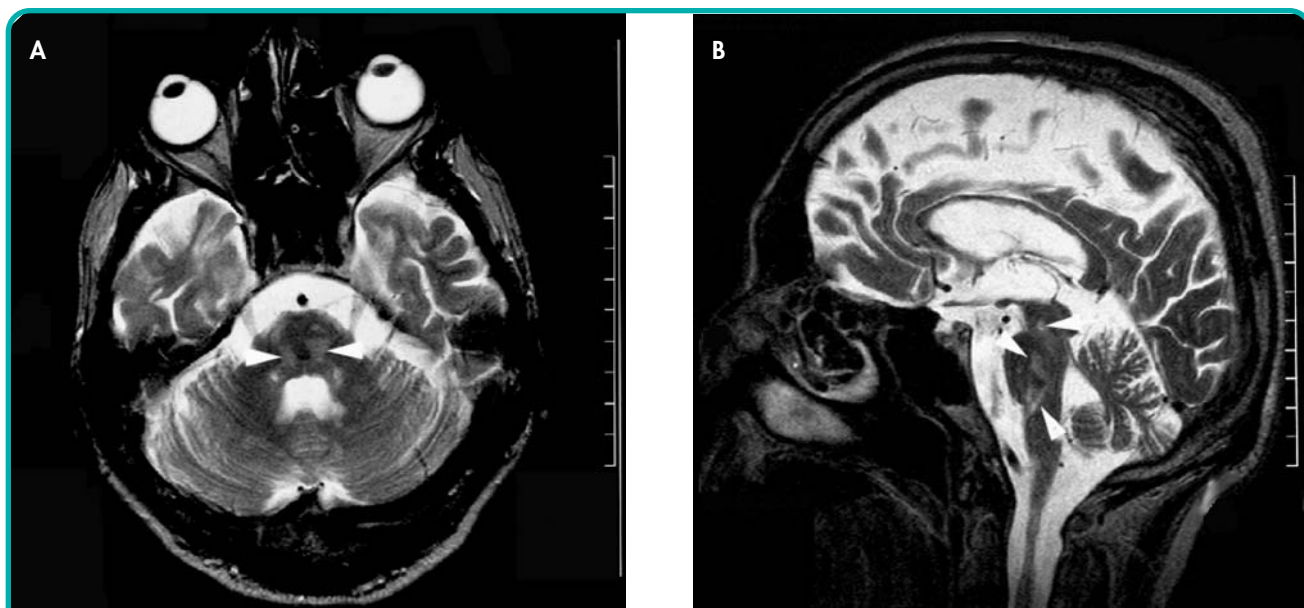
Magnetic resonance image (MRI) of the brain of a patient with multiple sclerosis and severe dysphagia. (A) Axial T2 image showing bilateral hyperintensities in the tegmentum of the pontomedullary junction (arrowheads pointing to only some of the lesions). (B) The sagittal T2 image shows that the hyperintensities extend from the tegmentum of the pontomedullary junction over the pons into the mesencephalon (arrowheads)
